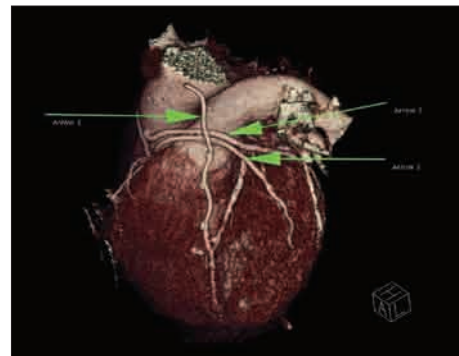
CT coronary angiography showing normal coronary artery
